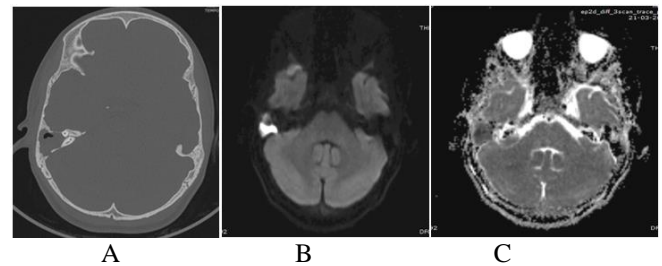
A 26 year old male patient presented with pain and discharge from right ear. HRCT temporal (a) bone showed soft tissue attenuating content in right middle ear and mastoid with extensive erosions. Corresponding area shows diffusion restriction with high signal in DWI (b) and low signal in ADC (c) indicating cholesteatoma.
